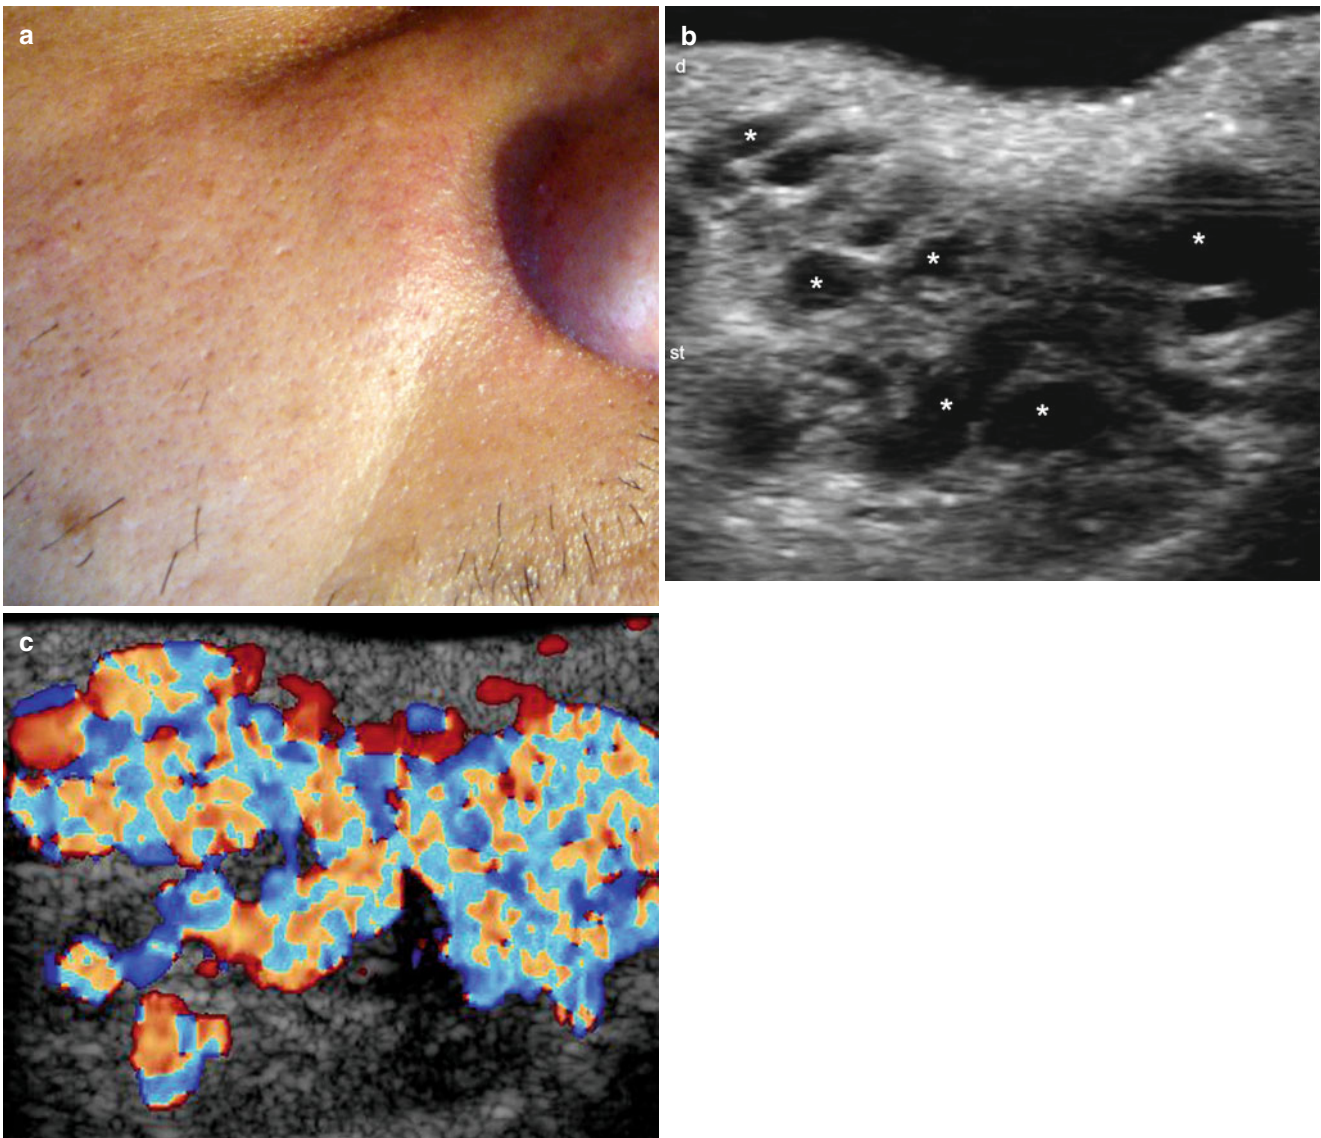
(a–e) High-Flow arteriovenous vascular malformation. (a) Clinical lesion shows slightly erythematous swelling in the right cheek. (b) Grey scale ultrasound image (transverse view) demonstrates multiple anechoic ducts (*) in the subcutaneous tissue without a solid
